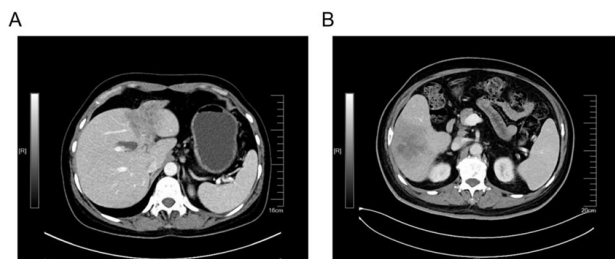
(A-B) Representative computed tomography (CT) images of patients with benign lesions of common bile and those with cholangiocarcinoma.
